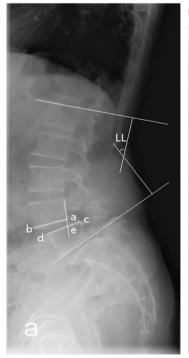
All parameters were measured on standing upright lateral radiographs of the spine (a) ce/cd, slipping percentage; LL whole lumbar lordosis (b) (a + b + c/3) intervertebral height (c) PI, pelvic incidence; SS, sacral slope (sacral inclination).
